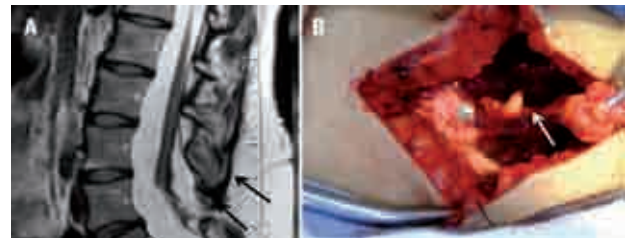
[A] T2-weighted MRI showing caudal lipoma with lipofibromatous talus penetrating the dura mater and adhering to the medullary conus, which was located in an abnormally low position (arrows). [B] Surgical view of a subcutaneous lipoma and lipofibromatous talus penetrating the dura mater (arrows).
